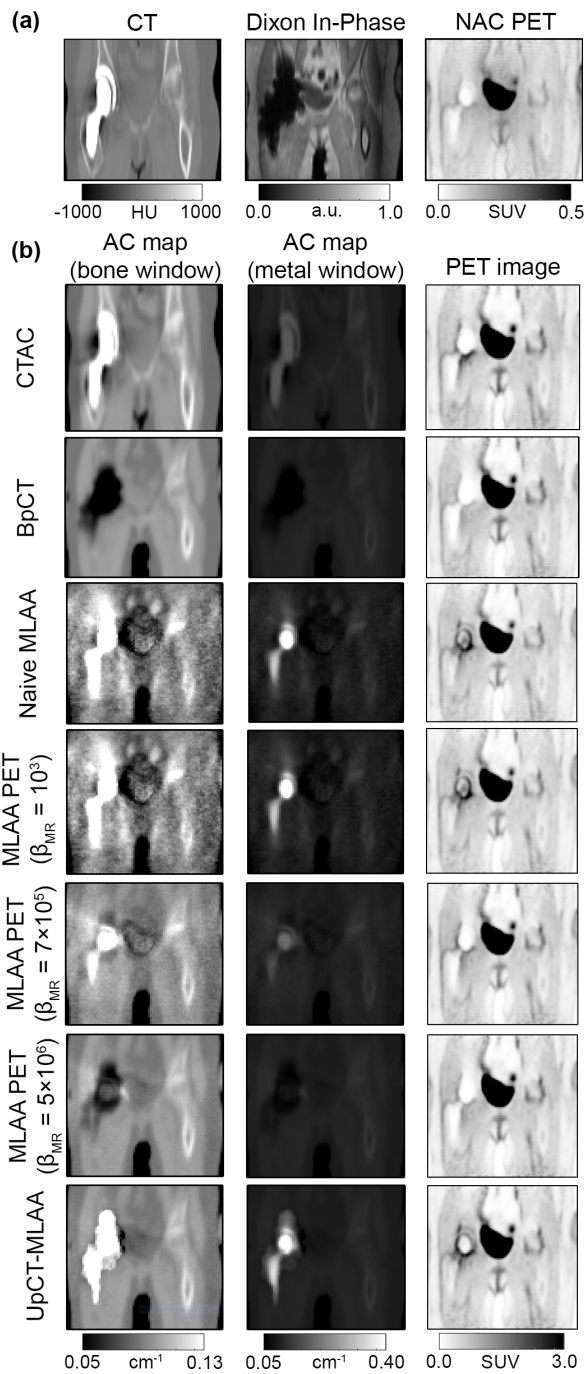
Representative images from metal implant patient #3 imaged with  $^{18}\text{F}$ -FDG. Shown are the CT, Dixon in-phase, and NAC PET images (a), AC maps (b, first and second column), and associated PET reconstructions (b, third column). The AC maps are shown in two different window levels to highlight bone and soft tissue (b, first column) and the metal implant (b, second column).
